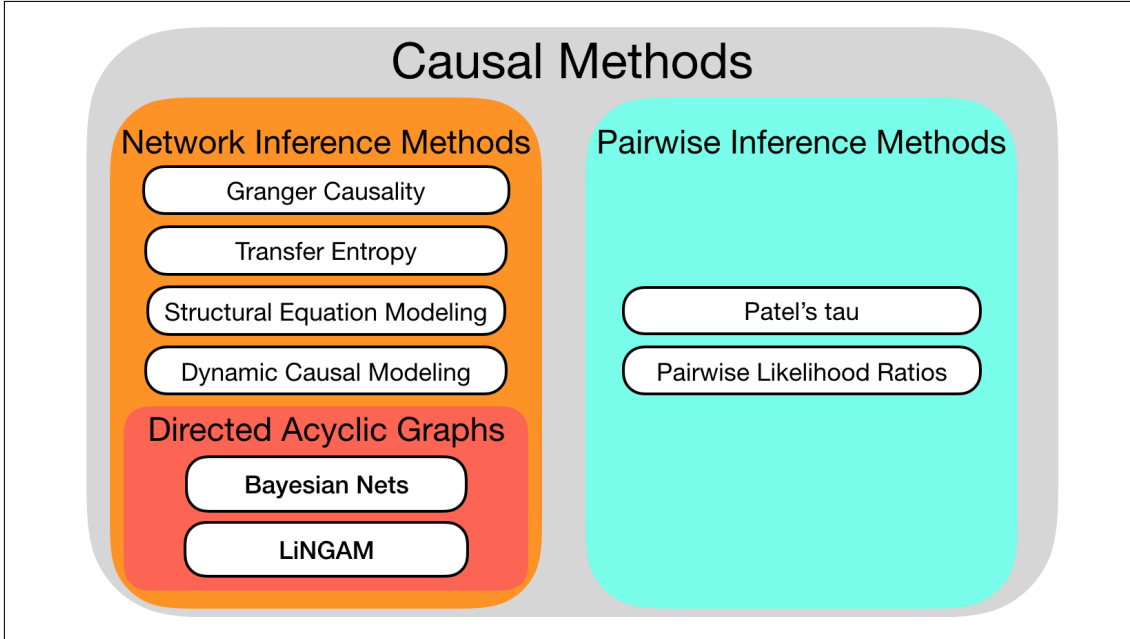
Causal research in functional Magnetic Resonance Imaging. The discussed methods can be divided into two families: Network Inference Methods, which are based on a one-step multivariate procedure, and Pairwise Inference Methods, which are based on a two-step pairwise inference procedures. As pairwise methods by definition establish causal connections on a node-by-node basis, the network as a whole cannot be guaranteed to be of any particular structure.
